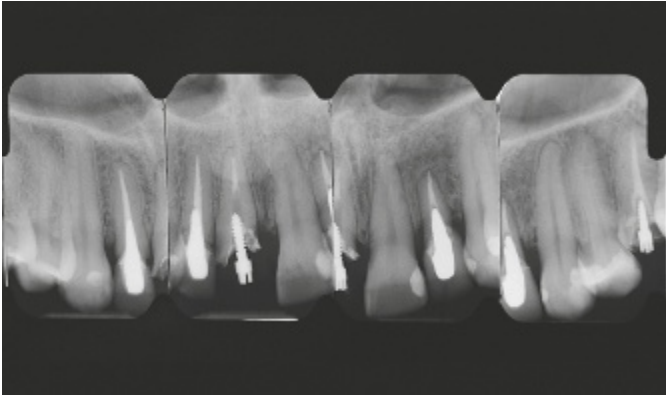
The preoperative radiographs for this case show, in the right central incisor, a significant reduction of tooth structure and an inappropriate post into the root. There is also a substantial reduction of the periodontal support around the left lateral incisor.
